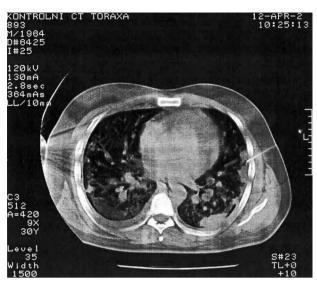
Transverse computer tomography scan (CT) of the chest obtained during the fine needle aspiration biopsy (FNAB) shows bilateral nodular consolidations representing metastases.
